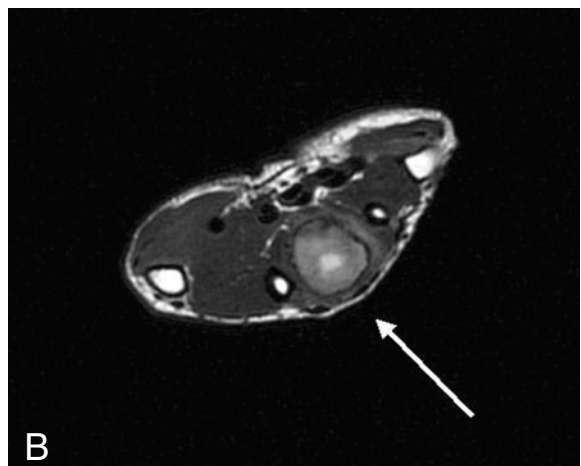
A: Low signal intensity on T1WI MRI of the left hand. B: High and heterogenous signal intensity is noted inside the lesion in T2WI.
